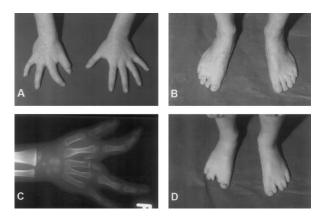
Limb defects observed in VI:9 and her son VII:3. *A*, Hands of VII:3. The right hand, shown after surgical removal of the 3d-ray bones, shows radial deviation of the 2d finger; the left hand is normal. *B*, Feet of VI:9. The right foot shows syndactyly of the 1st and 2d toes and of the 3d and 4th toes; the left foot is normal. *C*, Radiograph of right hand of VII:3 before surgery, showing normal metacarpalia, except for outgrowth of the 2d finger; radial deviation in the proximal interphalangeal joint of the 2d finger; absence of the 3d finger; and bony structures both between the 2d and 3d metacarpalia and on top of the 3d metacarpus. *D*, Feet of VII:3. The right foot is split, with syndactyly of the 1st and 2d toes and of the 3d and 4th toes and with hypoplasia of the 2d and 3d toes; the left foot is split, with syndactyly of the 1st and 2d toes and of the 3d and 4th toes and with hypoplasia of the 2d toes.
